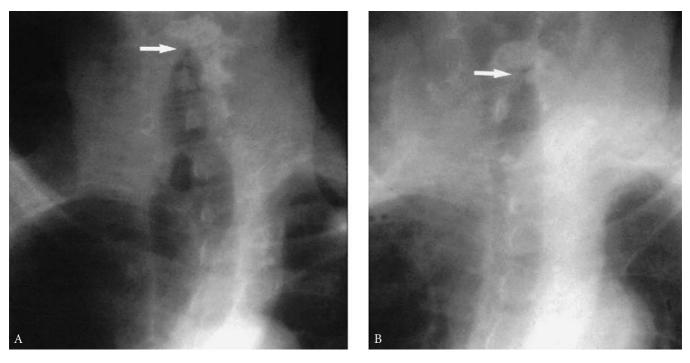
Roentgenogram of a patient with postintubation tracheoesophageal fistula. A, Note the distended esophagus, typical of this condition. Fistula is visible as a radiolucent circle. B, After repair, a normal tracheal air column is seen. Arrows mark the glottic level in both roentgenograms.
